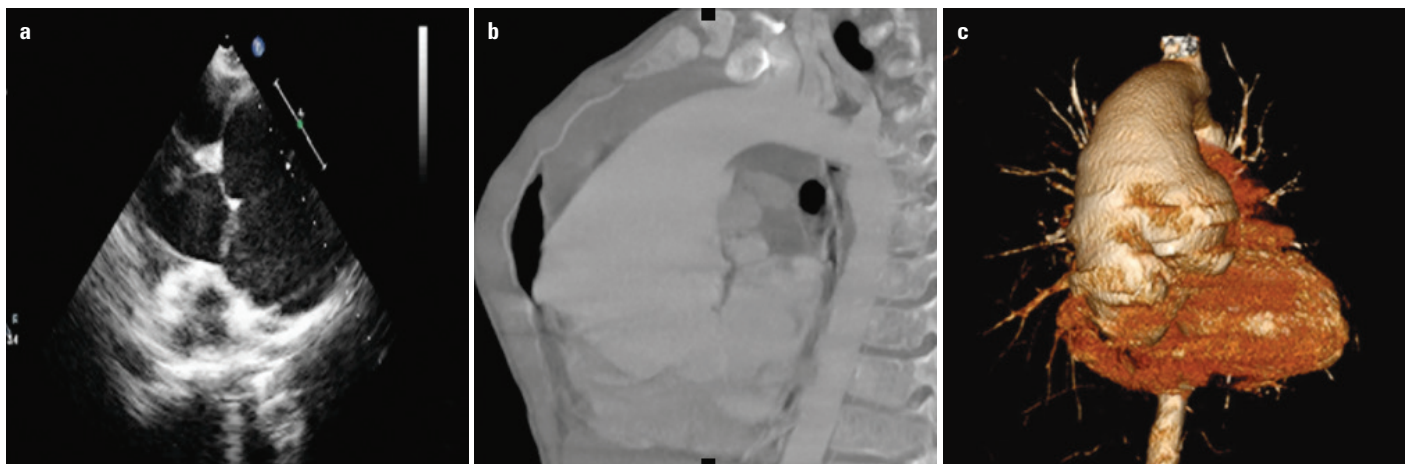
(a) The fusiform dilatation of the sinus of Valsalva in echocardiographic evaluation. (b, c) The aneurysmatic dilatation of the aortic root and arcus aorta on computed tomography angiographic images
